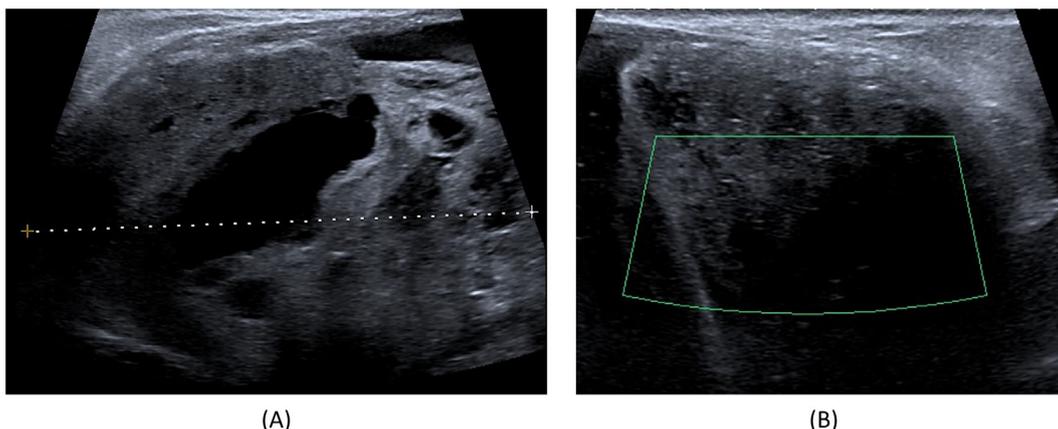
(A and B) Ultrasonography excluded vascular herniation and revealed the complex nature of this multi-septated cyst.
